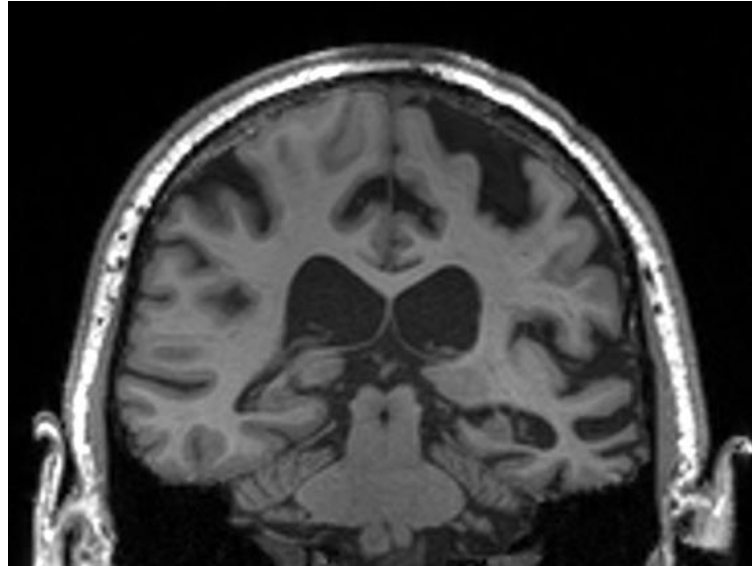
Coronal volumetric T1-weighted MRI of a patient with lvPPA. The scan shows characteristic asymmetric atrophy of left tempoparietal cortex. The left hemisphere is on the right side.
